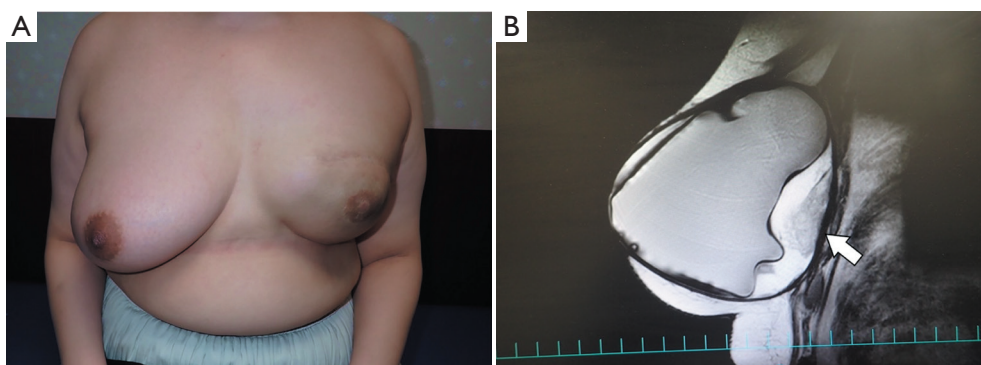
Clinical findings of case 2. (A) Picture of case 2 7-year postoperatively. Contraction and color change of the left breast are observed. (B) Magnetic resonance imaging findings in case 2. Fluid retention, including sediments around the implant, are observed (arrows), and implant shape changes are observed.
